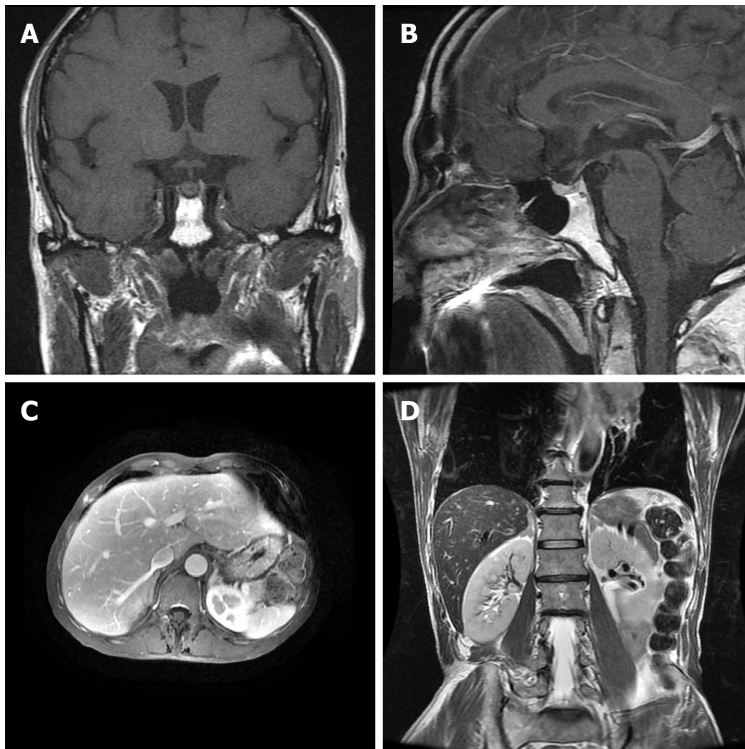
Magnetic resonance images of the head and the epigastrum. A, B: Magnetic resonance imaging (MRI) of the pituitary. No obvious abnormalities were observed. Arrows are labeling the pituitary in both views; C, D: MRI of the epigastrum with bilateral adrenal thickening detected. Arrows are labeling the epigastrum in both views.
